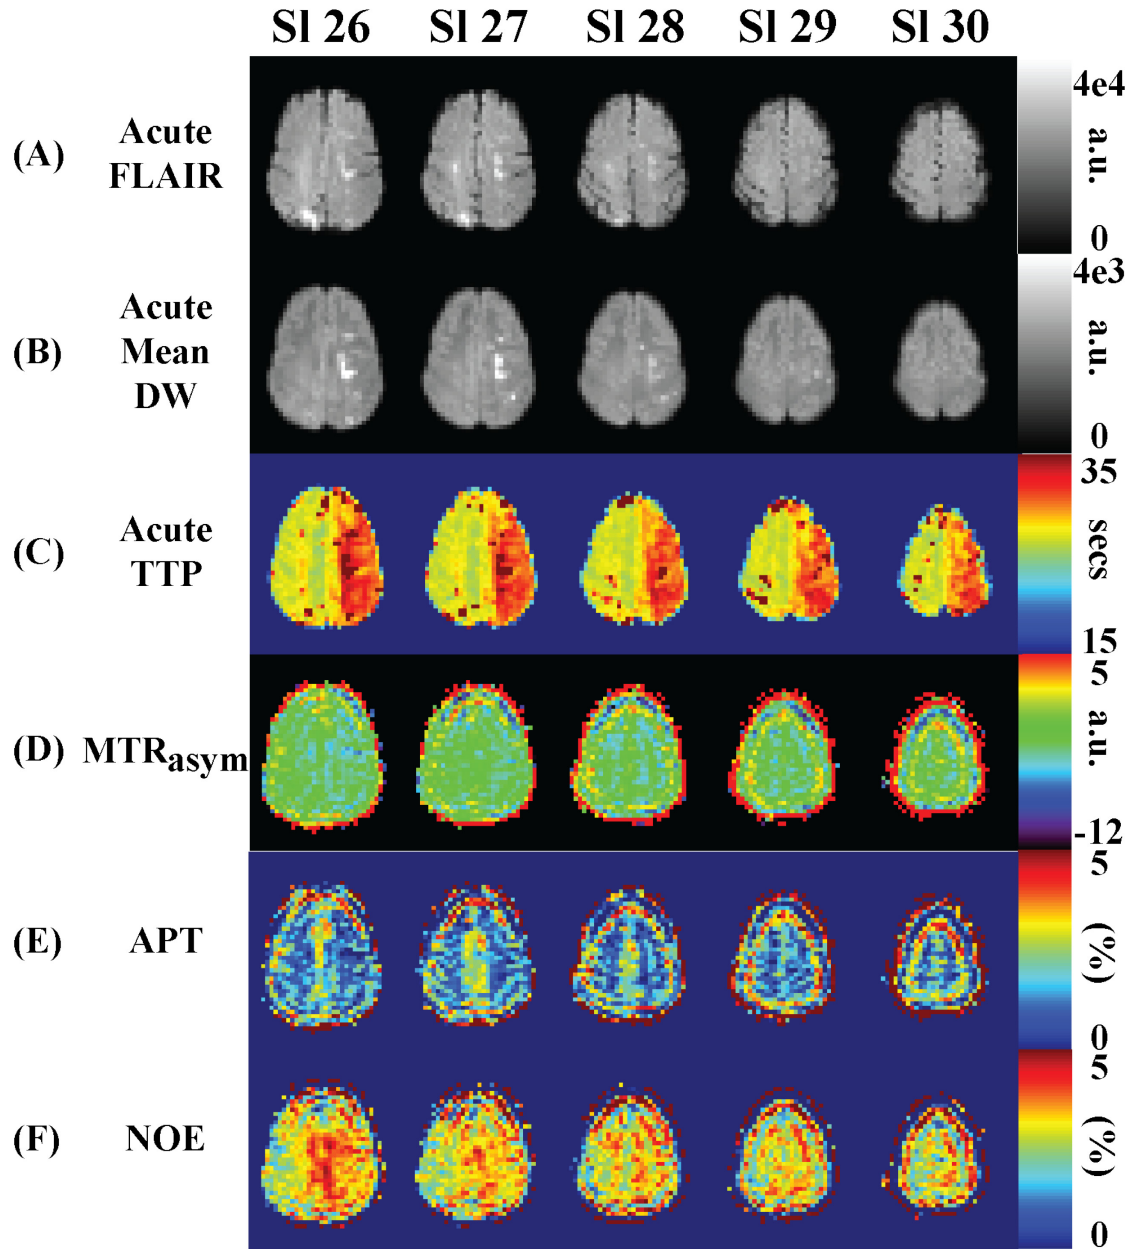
Processed data for carotid artery stenosis patient (Slices 26-30) (displayed in radiologic convention). (A) Acute FLAIR scan (B) Acute Mean Diffusion Weighted scan (C) Acute Time to Peak scan (D)  $MTR_{\text{asymmetry}}(3.5 \text{ ppm})$  (pH-weighted) (E) APT (F) NOE
